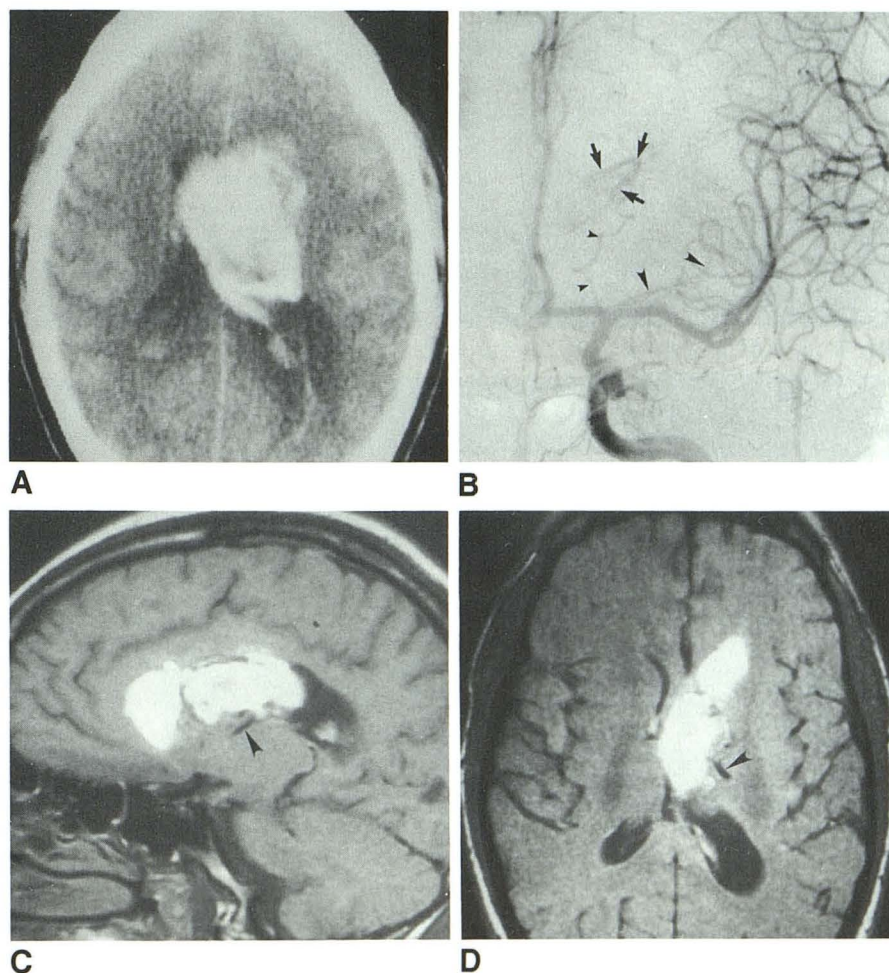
A, Unenhanced CT scan at time of admission reveals intraventricular hemorrhage and acute hydrocephalus.
